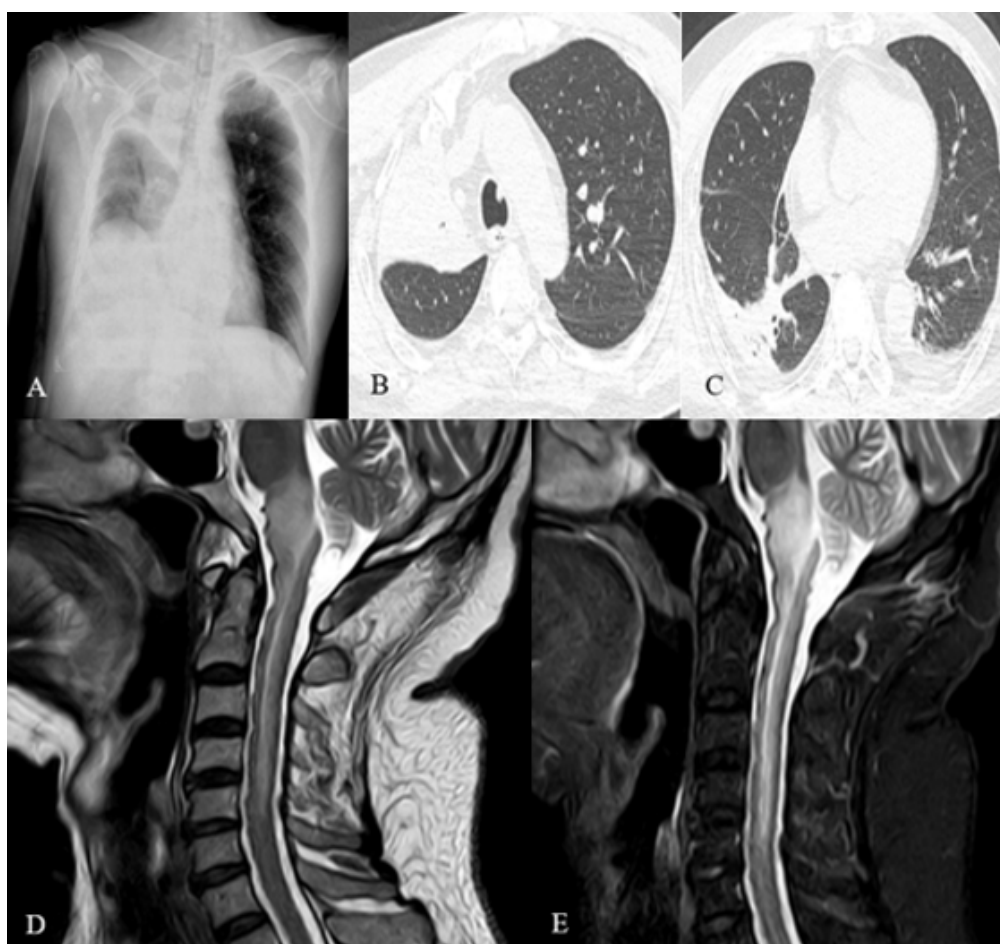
A 62-year-old male patient with Cognard type V dAVF: Chest imaging and follow-up MRI after the onset of respiratory failure. (A): Chest X-ray shows reduced lung volume with right upper lobe atelectasis and diffuse opacities. (B), (C): Chest CT demonstrates consolidation and atelectasis of the right lung. (D), (E): Sagittal T2-Weighted and STIR images of the cervical spine show progression of spinal cord edema extending to C5.
